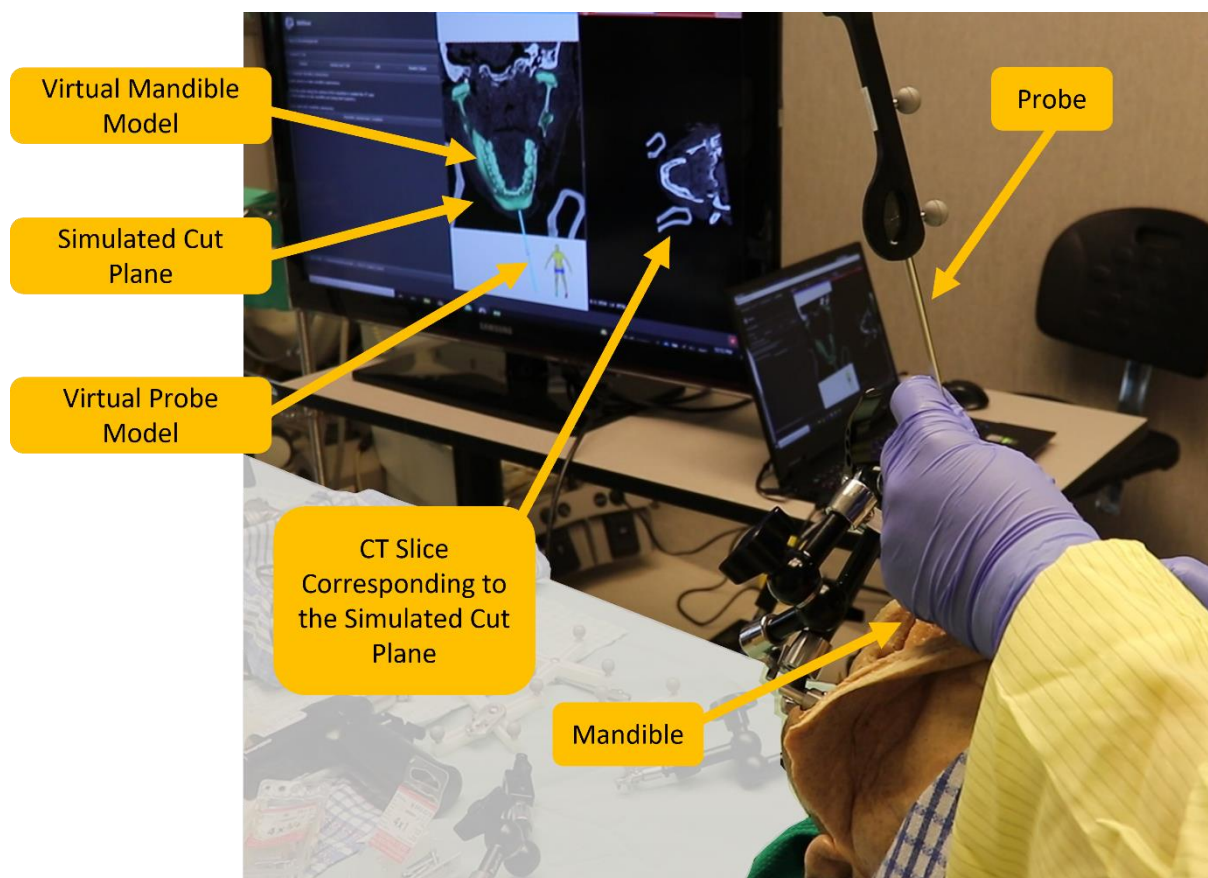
Mandible CT visualisation for defining the mandible cut planes.
